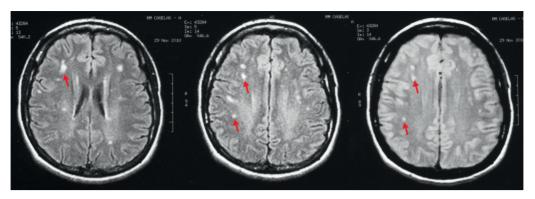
Brain MRI showing small rounded lesions (arrows) in the subcortical white-matter of both hemispheres.
